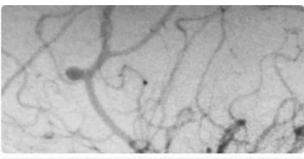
Angio-computed tomography showing bilateral pericallosal artery aneurysms in mirror position.
